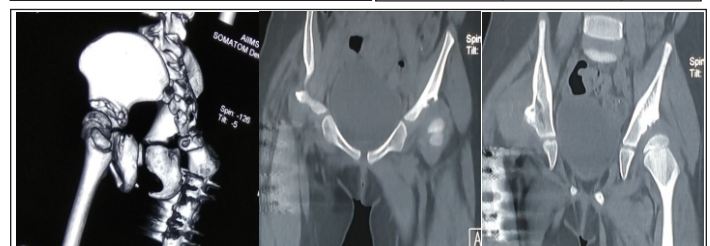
8a,b,c-Case 2, CT assessment before revision surgery
